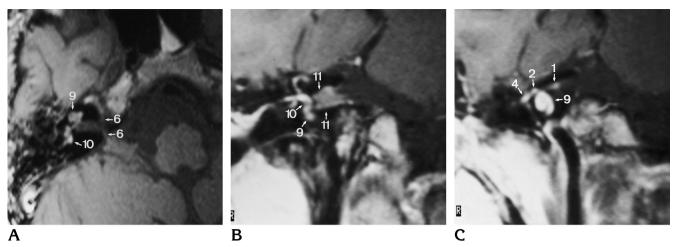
Noncontrast transverse (500/15/2) (*A*) and contrast-enhanced coronal (600/20/4) (*B* and *C*) T1-weighted images, obtained 38 (*A*) and 65 (*B* and *C*) days after transverse fracture, show a fracture line (*b*) coursing through the internal auditory canal and associated palsy of immediate onset. A hyperintense hematoma within the cochlea (*9*) and vestibule (*10*) was seen 38 days after trauma (*A*). Sixty-five days after trauma, the distal intrameatal segment (*1*) and superoinferior vestibulocochlear nerve (*11*) within the internal auditory canal show intense enhancement. The cochlea (*9*) and vestibule/semicircular canals (*10*) are also intensely enhanced. (The noncontrast images, not depicted, no longer showed the hyperintense hematoma within the cochlea/vestibule.) Note intense enhancement of the labyrinthine (*2*) and proximal tympanic (*4*) segments.
